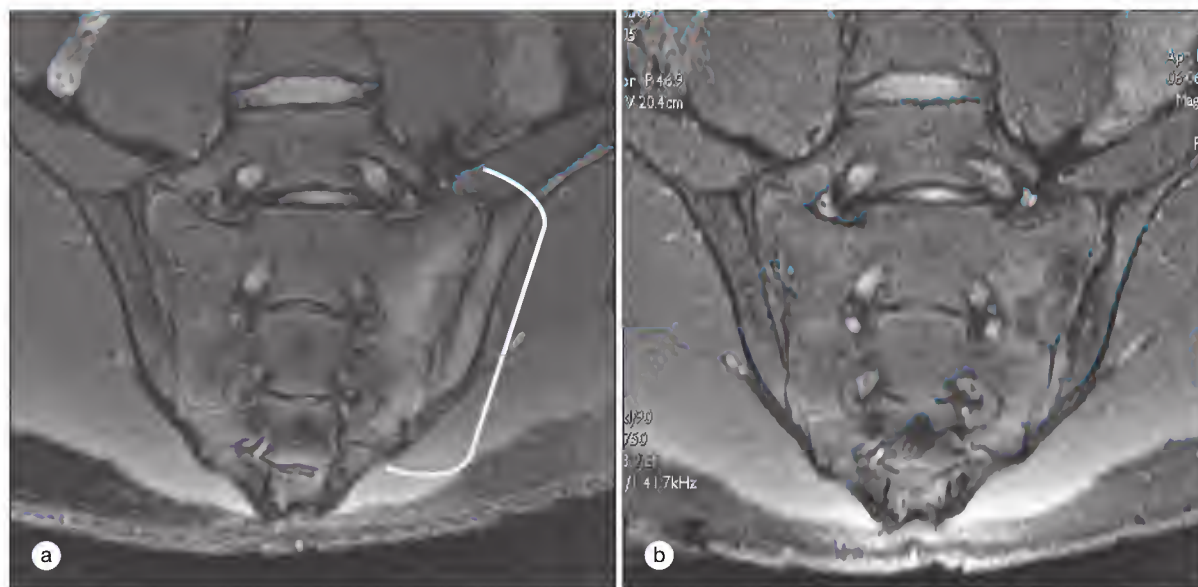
Short tau inversion recovery (STIR) magnetic resonance image of the sacroiliac joints of a 16-year-old boy with a 3-month history of gluteal pain and a 3-year history of peripheral arthritis and enthesitis before (a) and 14 weeks after (b) treatment with infliximab, 5 mg/kg, at baseline and at weeks 2 and 6. Note edema of the iliac bone and sacrum (line) and part of the inferior quadrant of the sacrum on the opposite side, which cleared after treatment.
